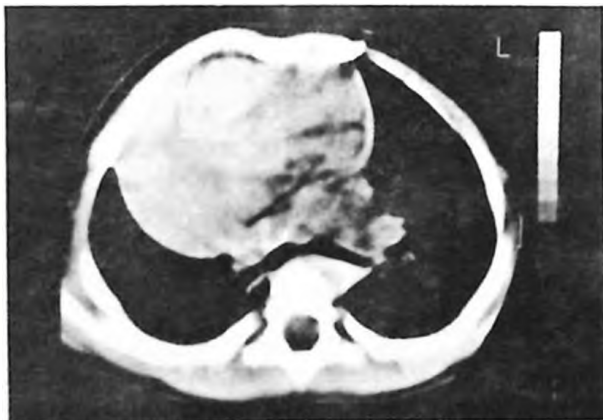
CT scan showing anterior mediastinal mass with heterogeneous density enhancement.
